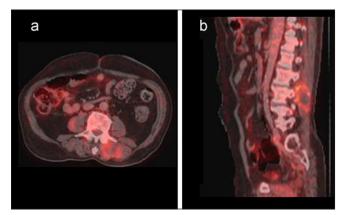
Transaxial and sagittal fused 18 - FDG PET CT images show uptake in peripherally enhancing hypodense lesions in the left erector spinae muscle at the level of L3/4 vertebra with SUVmax 5.3
